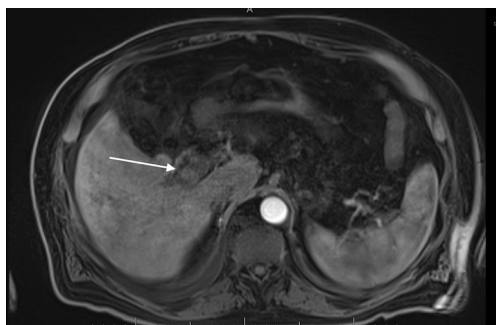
Different sequence from the same patient as *Figure 2*. Contrast MRI in the arterial phase shows early arterial enhancement in the thrombosed main portal vein differentiating it from bland thrombus. Main portal vein tumor thrombus is classified as Shi type III.
